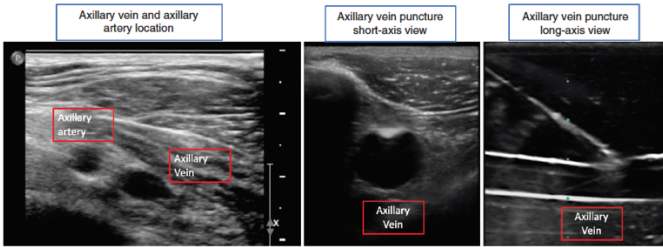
Ultrasound axillary vein localization and puncture in short and long-axis views.
